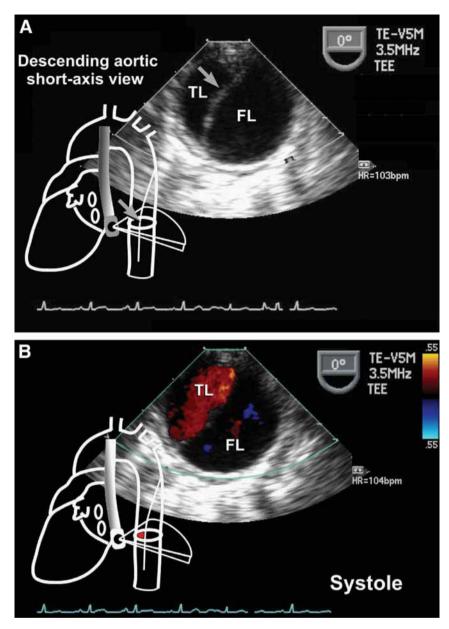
Transesophageal descending thoracic aorta short-axis in the same patient in Fig. 1A,B. Color flow Doppler shows systolic flow within the true lumen (TL). Compare this to the false lumen (FL). (Please *see* companion DVD for corresponding video.)
